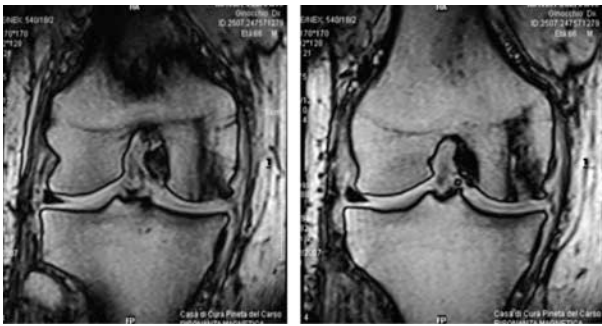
Preoperative MRI of right knee with knee osteoarthritis of the medial and hotbed of osteonecrosis
